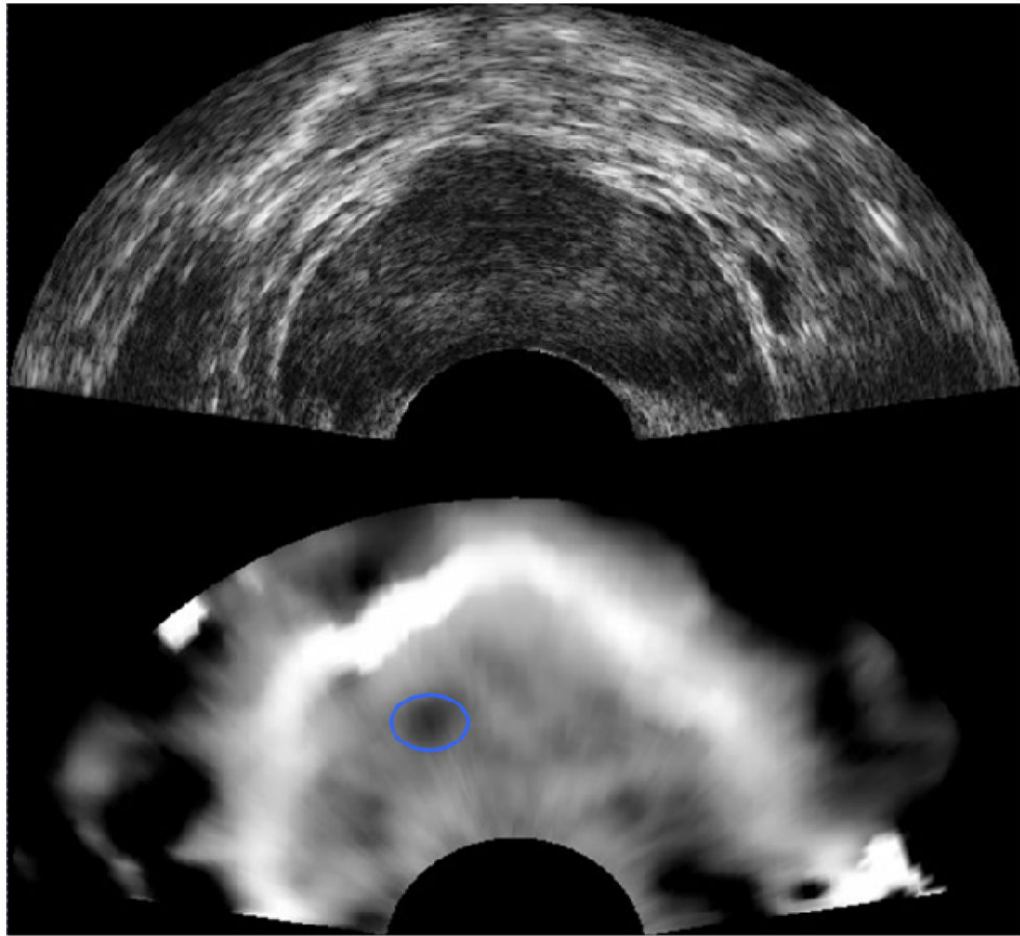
Prostate B-mode sonogram (upper image) and corresponding elastogram (lower image) showing a small dark area (circled) corresponding to a malignancy. This focus is not visible on the sonogram. Images courtesy of Kaisar Alam, Riverside Research Institute.
